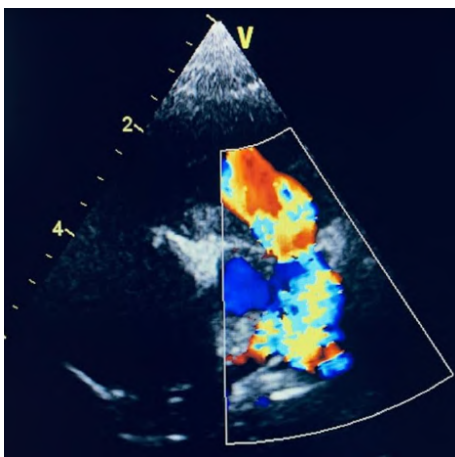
2D echocardiography: Biventricular concentric hypertrophy (predominantly left). Interatrial septal defect ostium secundum: 4.5 mm in diameter.
